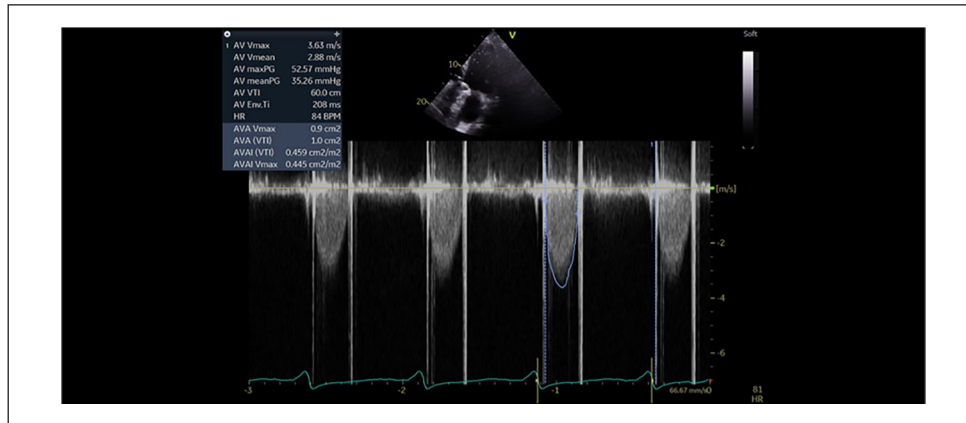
Transthoracic echocardiogram after initiation of thrombolytic and anticoagulation therapy. Mechanical aortic valve with a peak velocity of 3.6 m/s and mean pressure gradient of 35 mmHg.
